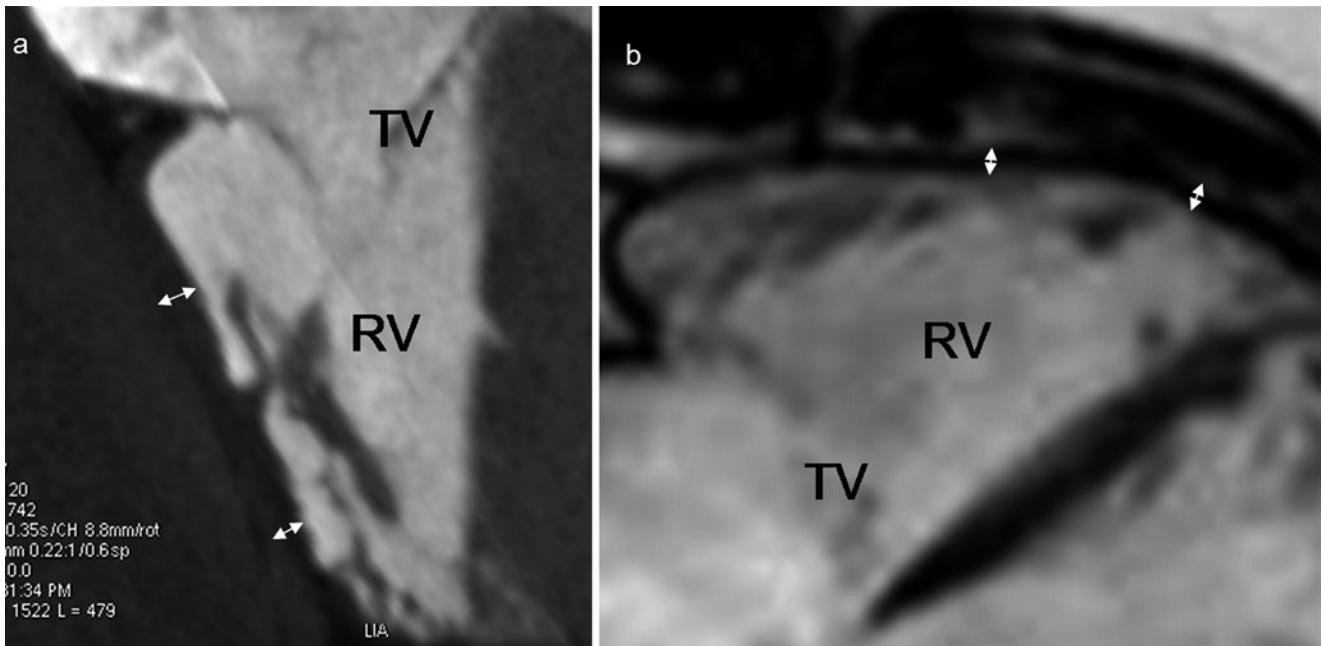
(a) Slice image by CT and (b) MRI showing the remarkable thin wall of the right ventricle (RV). TV tricuspid valve
